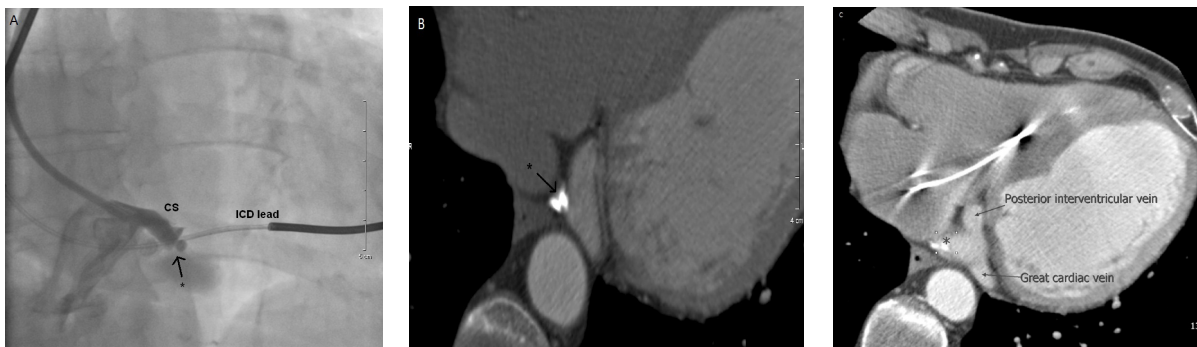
A foreign material was seen in the coronary sinus angiography (Fig. 1A). A subsequent multislice computed tomography confirmed CS occlusion and foreign metallic materials (Fig. 1B, Fig. 1C; * indicates foreign material)
